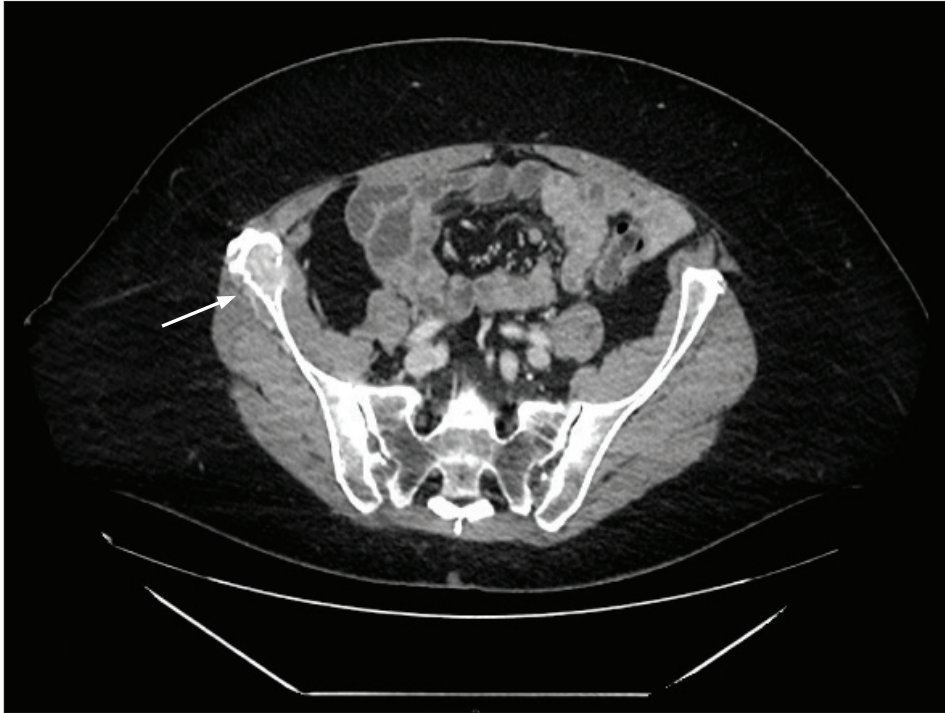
Computed tomography scan showing a new right iliac lesion in September 2023.
